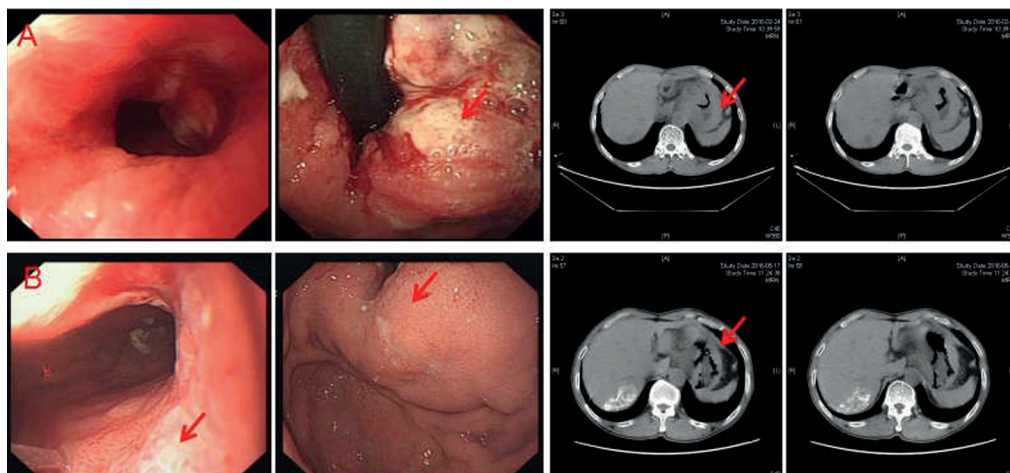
Typical case 3. Comparison of electron gastroscopy and CT images before (A) and after (B) intervention.
